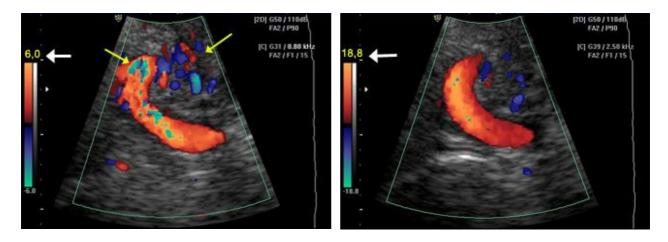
Aliasing of color doppler imaging and artefacts of color (left). Color image shows regions of aliased flow (yellow arrows). This problem is avoided by reducing color gain and increasing pulse repetition frequency (Right).
